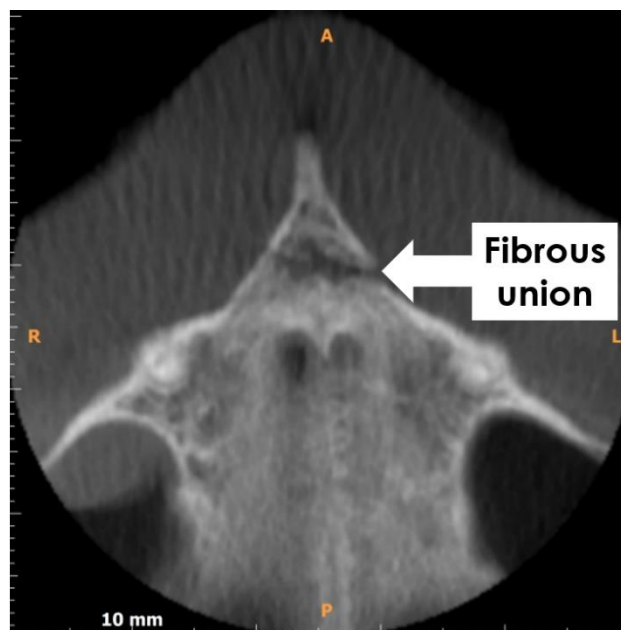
CBCT axial view revealed fracture of the anterior nasal spine, with (likely) fibrous union. Further clinical examination confirmed an absence of symptoms and normal sensation within this region
